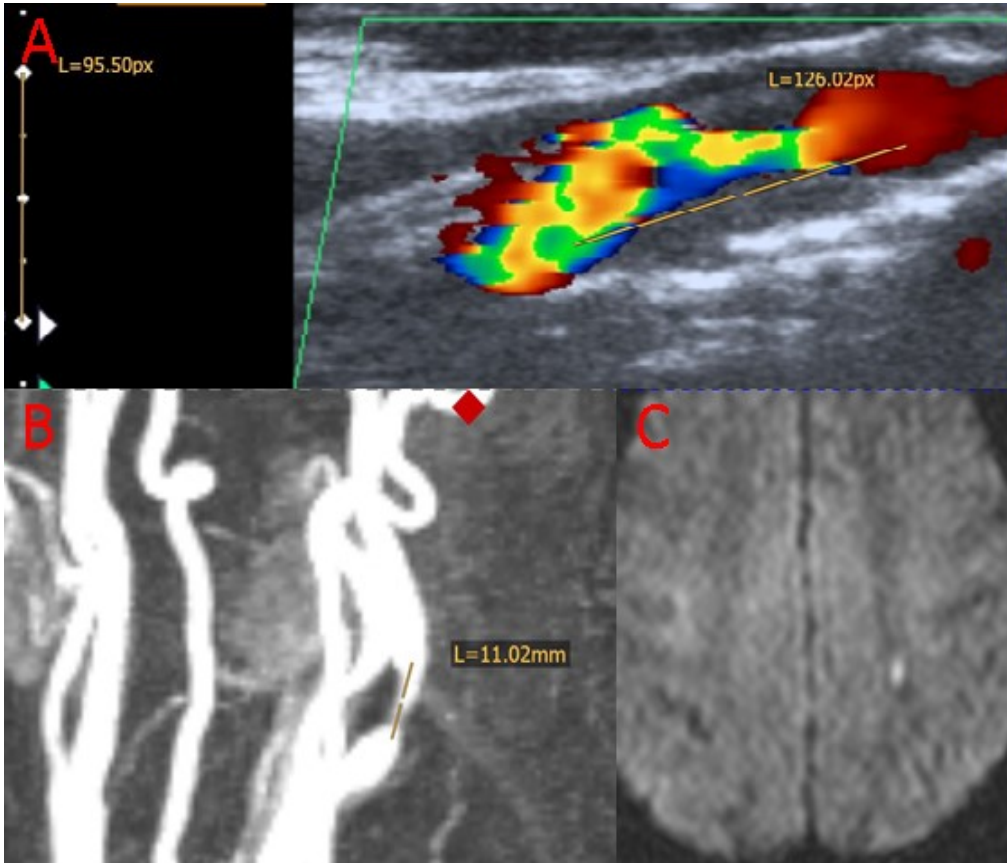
A. Ultrasound examination (patient 102) showing soft plaques causing an ICAD of 90% with a length of 13 mm on the left side, B. MRA revealing an 11 mm long ICAD on the left side, C. DWI-MRI showing a small infarction in the left centrum semioval center
